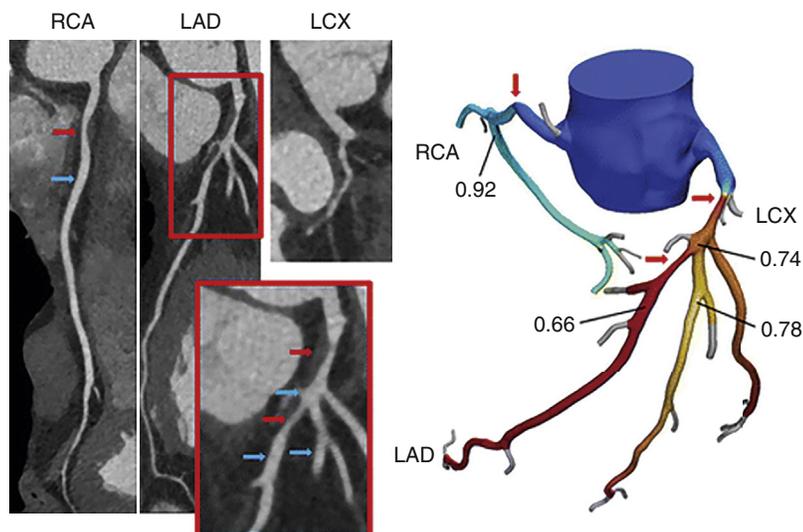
FFR_{CT} assessment in vessels with serial lesions in a 53-year-old man with typical angina. *Left:* Coronary computed tomography angiography curved multiplanar reconstructions demonstrate a proximal 60% right coronary artery (RCA) stenosis (red arrow) and two serial stenoses in the left anterior descending artery (LAD) (one lesion in the proximal segment with 70% or greater diameter stenosis, and a 50% to 69% diameter stenosis lesion distal to the takeoff of the second diagonal [red arrows]). Blue arrows indicate where the FFR_{CT} values were assessed. *Right:* in the FFR_{CT} three-dimensional model, the FFR_{CT} value 10 mm distal to the proximal LAD stenosis was 0.74 and thus had hemodynamic significance, whereas FFR_{CT} 15 mm distal to the second LAD stenosis was 0.66. FFR_{CT} 10 mm distal to the lower border of the proximal RCA stenosis was 0.92, thus this lesion had low likelihood of being hemodynamically significant. Of note, pressure recovery was observed in the proximal part of the second diagonal with a step-up in FFR_{CT} from 0.74 in the LAD to 0.78 when moving downstream the diagonal branch. LCX = left circumflex coronary artery. (From Nørgaard BL, et al. Coronary CT angiography-derived fractional flow reserve testing in patients with stable coronary artery disease: recommendations on interpretation and reporting. *Radiol Cardiothorac Imaging* 2019;1:e190050.)
